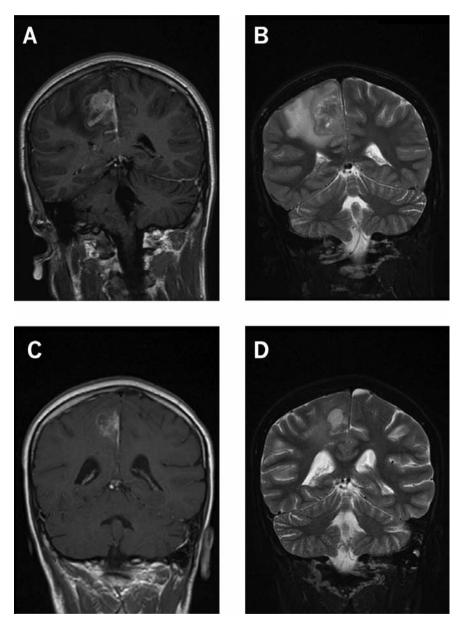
Magnetic resonance imaging of the brain, showing T1-post contrast (images on the left, A and C) as well as T2 flair images (images on the right, B and D). Images A and B demonstrate metastatic lesions in the right parietal lesion prior to radiation therapy. Images C and D were taken one month after radiation therapy and demonstrate an approximately 1/3 decrease in the size of the brain metastases as well as decrease in the surrounding brain edema.
